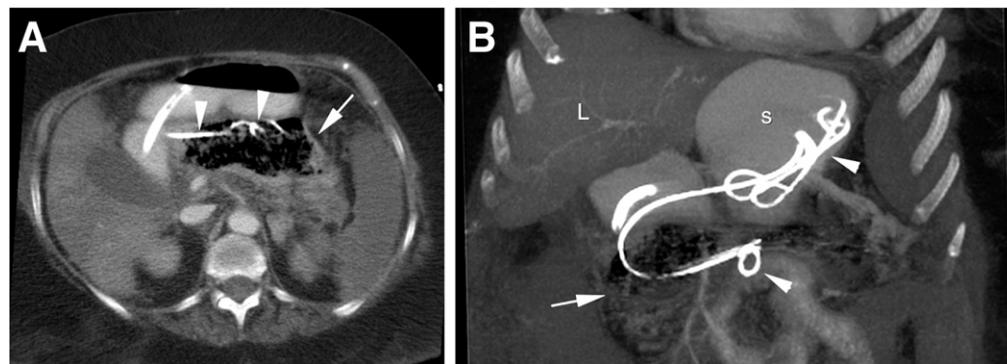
ETD: a 63-year-old woman with infected necrotizing pancreatitis. Axial CT (A) and coronal reconstructed mean intensity projection (B) show an infected pancreatic collection (arrow) with an endoscopic pigtail drain (arrowheads) positioned inside the collection (L, liver; S, stomach).
